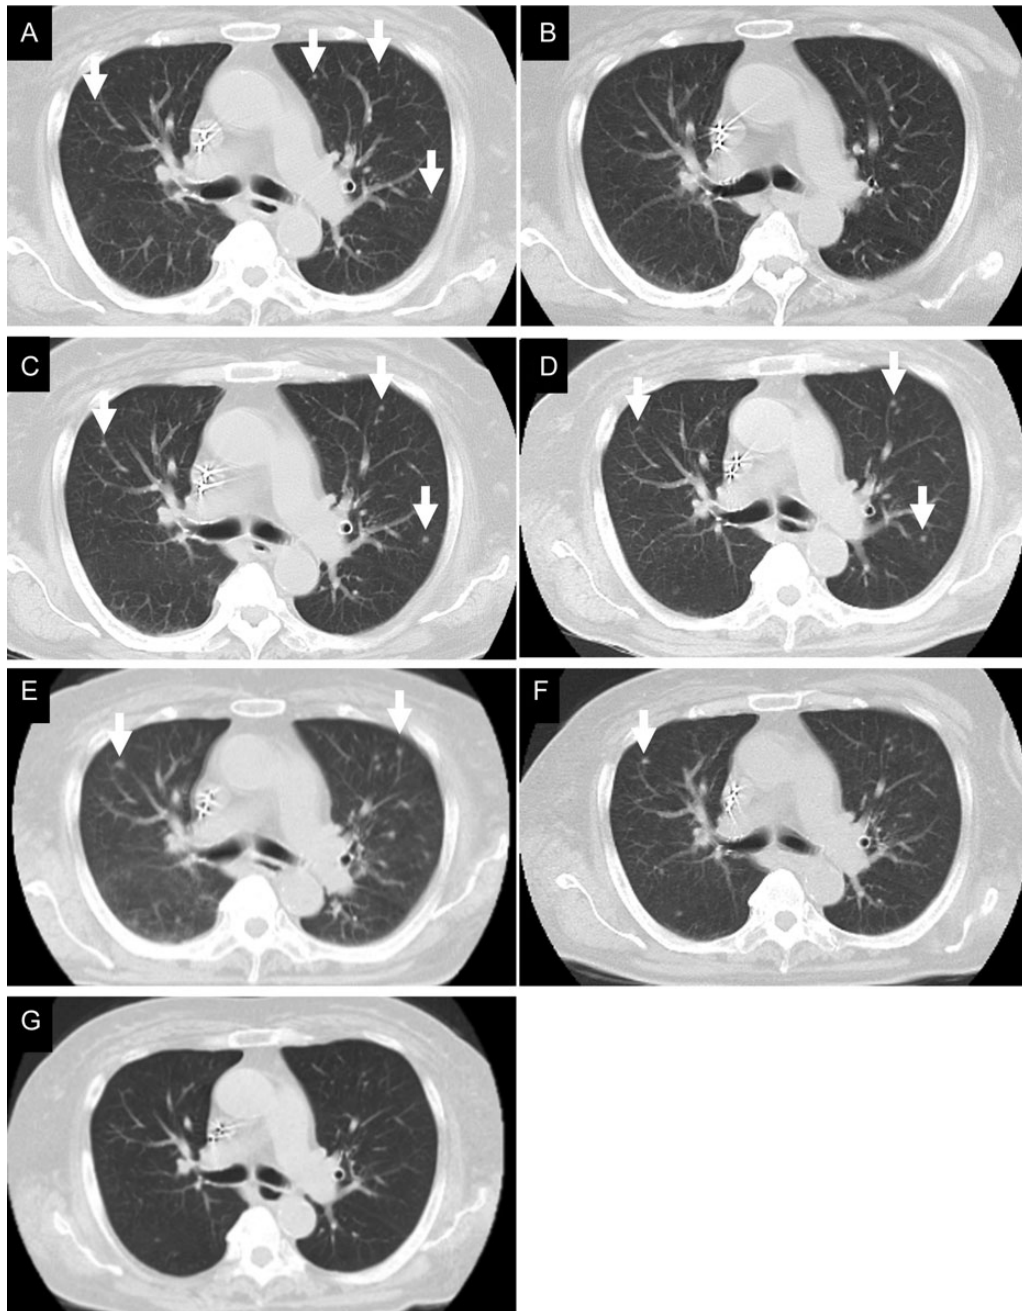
Images of computed tomography of the chest. Multiple lung nodules were incidentally found in April 2012 (A); no lung nodules were seen in April 2011 (B). The size of the nodular lesions progressively increased in June 2012 (C) and September (D). In spite of the initiation of antituberculosis drugs in September 2012, the granulomas increased in size in October 2012 (E). In November 2012, 1 month after the discontinuation of antituberculosis drugs and vildagliptin, the size of the granulomas decreased (F). In February 2013, 4 months after the discontinuation of these drugs, most of the granulomas were no longer detectable (G).
